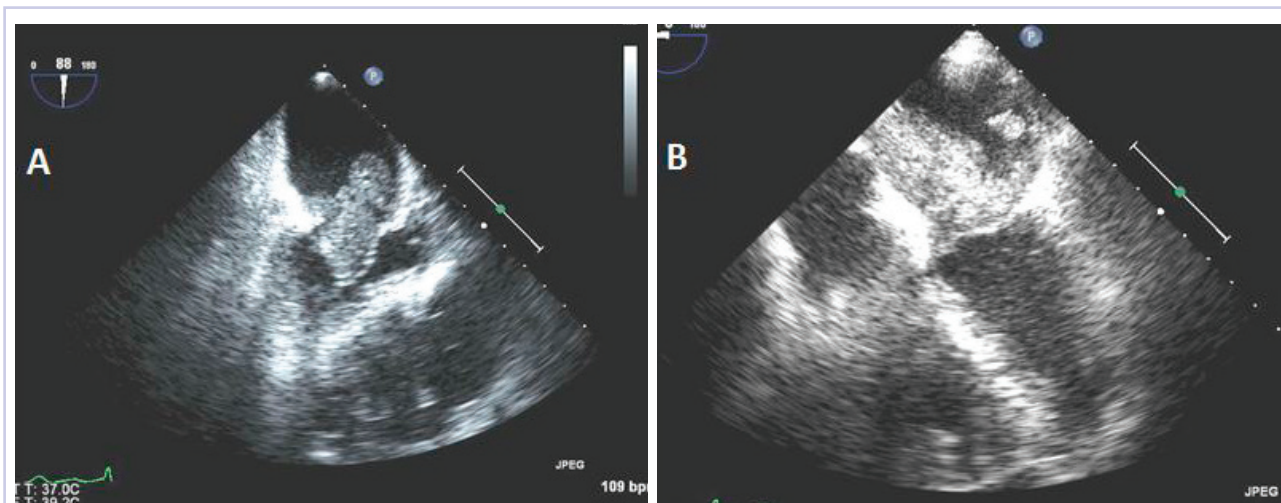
A transesophageal echocardiogram confirmed the presence of a large left atrial mass: A, 2 chamber view, and B, 4 chamber view.
